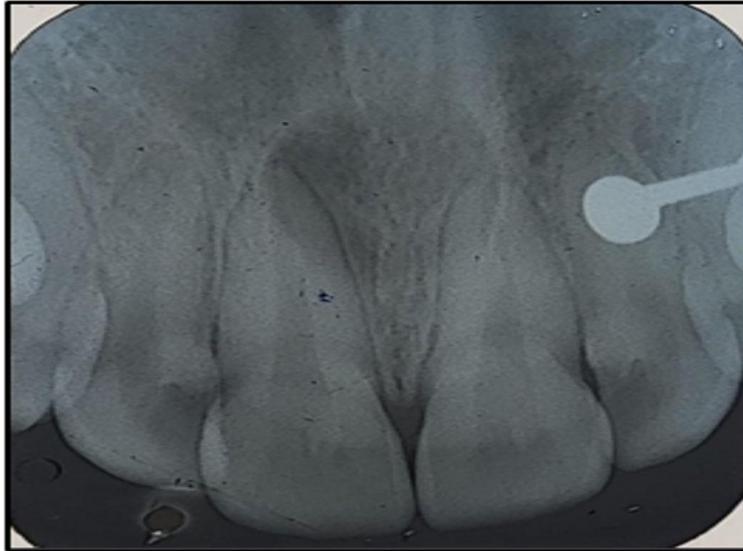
Intraoral periapical radiograph of 11,21
